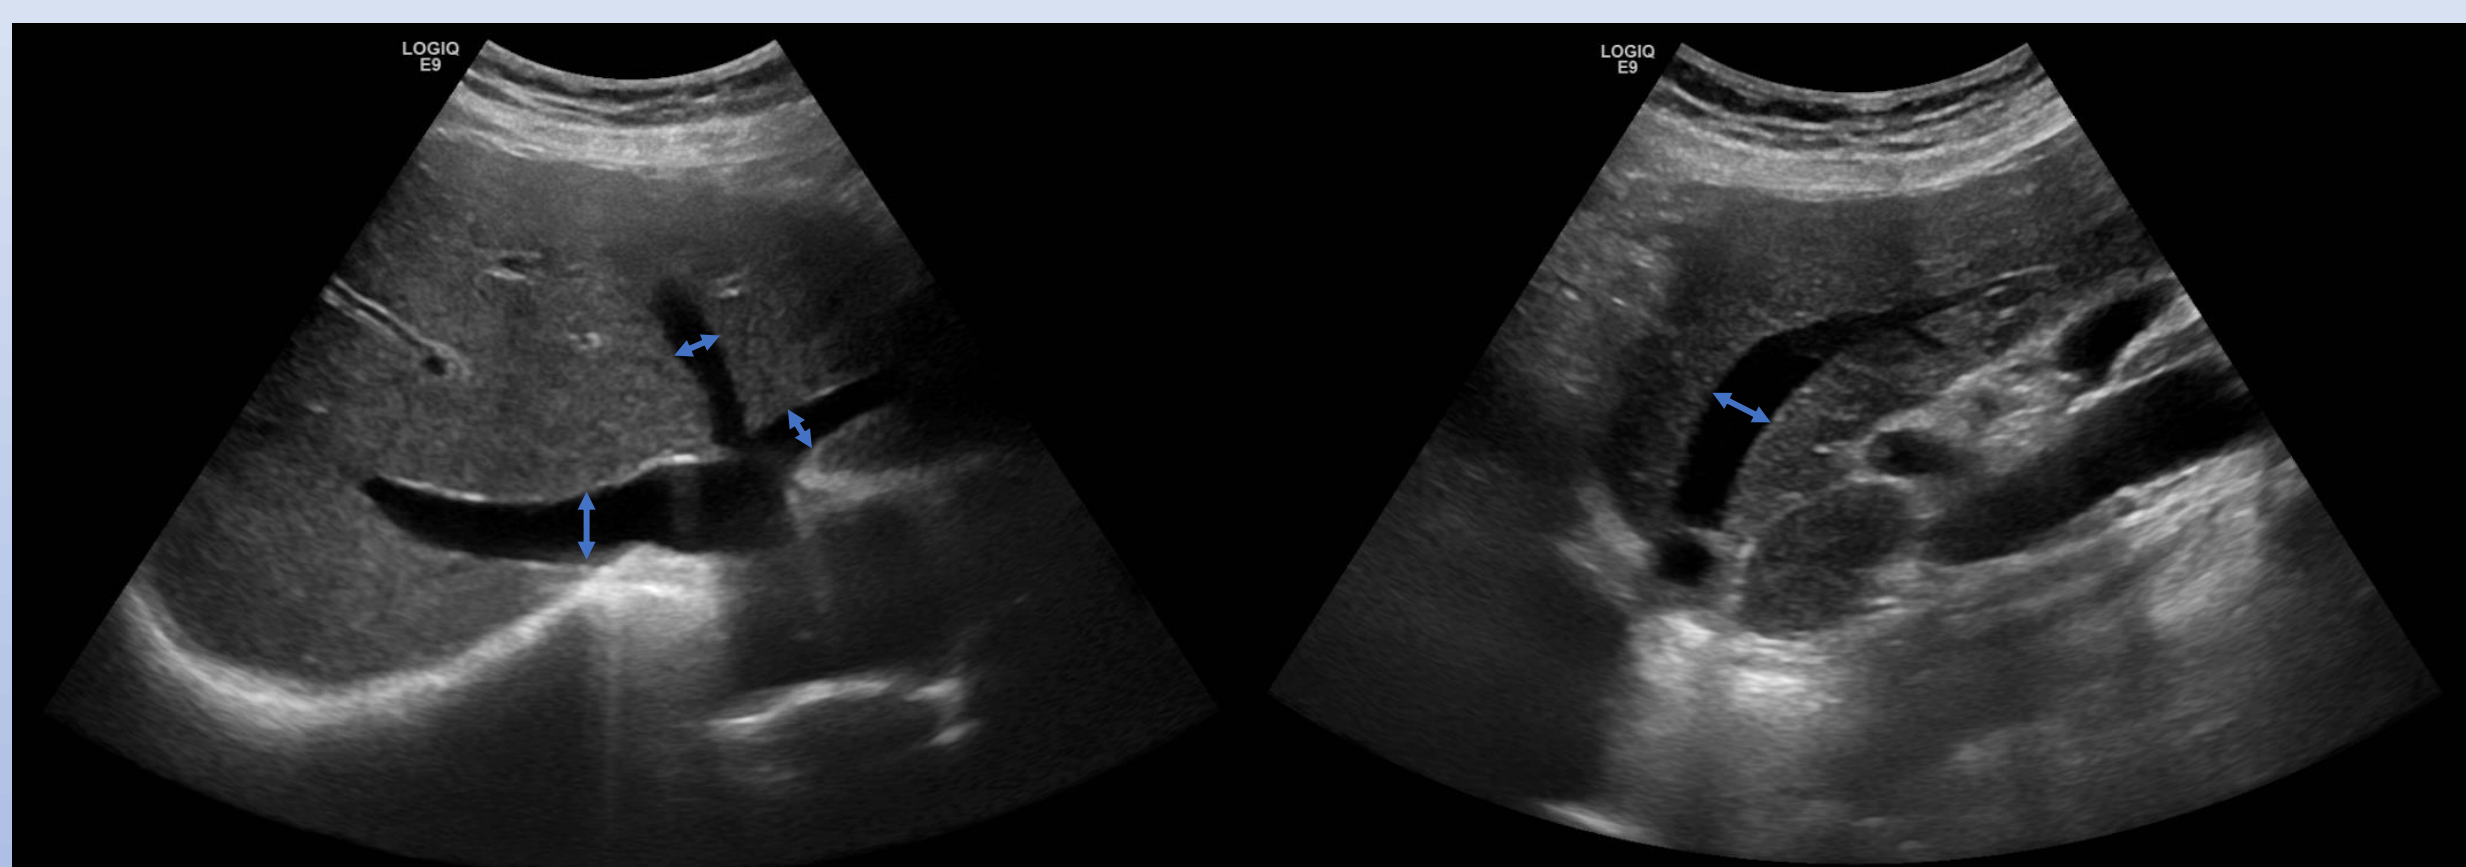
Ultrasound images demonstrating dilated hepatic veins. Diameter of >8mm is consistent with congestion.
